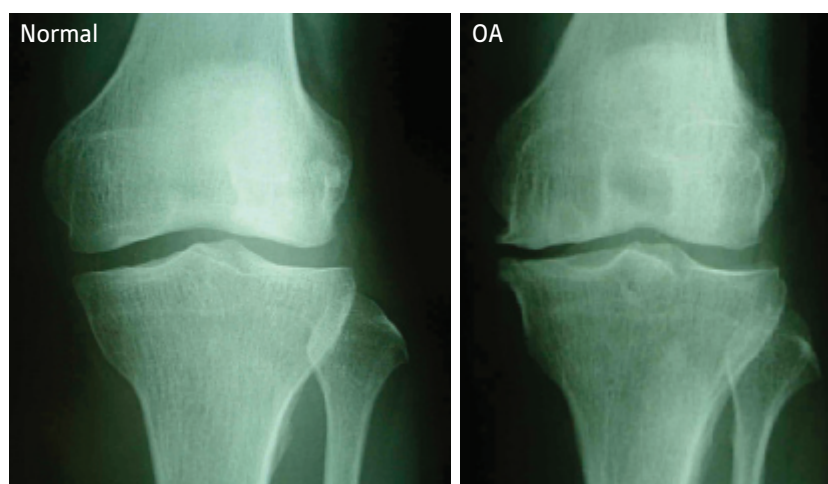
Radiographs of normal (left) and OA (right) knees. The medial joint space has decreased with OA and an osteophyte (bone spur) has formed.
